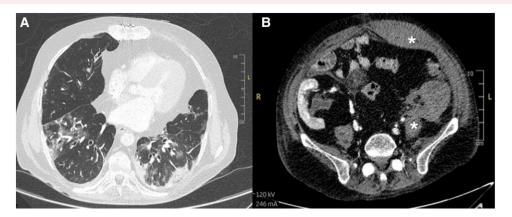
(A) Chest computer tomography, patchy parenchymal opacities in all lobes with ground glass pattern suggestive of alveolar haemorrhage. Moderate pericardial effusion. (B) Left retroperitoneal haematoma, abdominal wall haematoma in the anterior rectus abdominis, contrast leakage due to active bleeding from the left epigastric artery. *marking haematoma. Computer tomography (CT).
